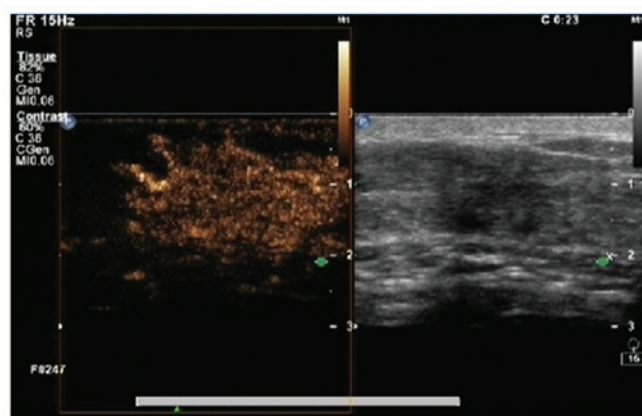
Ultrasound angiography of the left breast showing a slightly lower mass enhancement deep in the left nipple (left panel, contrast-enhanced tumor; right panel, appearance of the mass on B-ultrasound).
